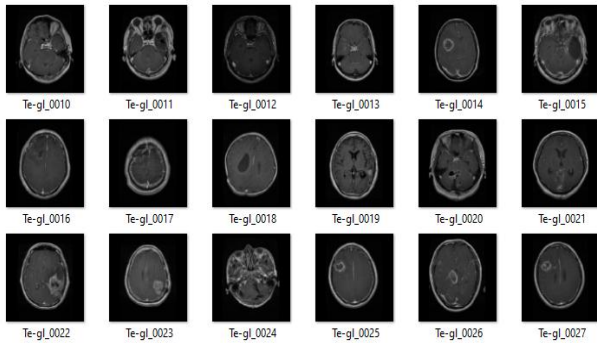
The Glioma MRI Images dataset from Kaggle.
